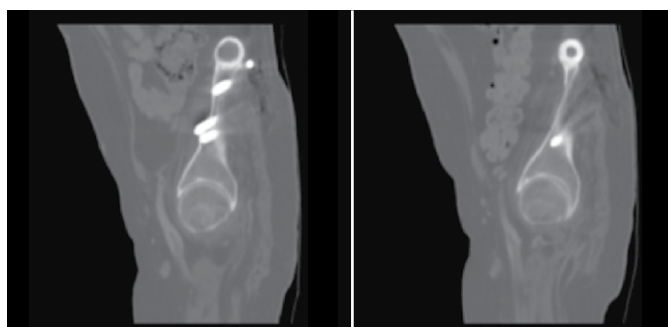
Computed tomography showing integration of allograft on both iliacs one year and five months after surgery.
